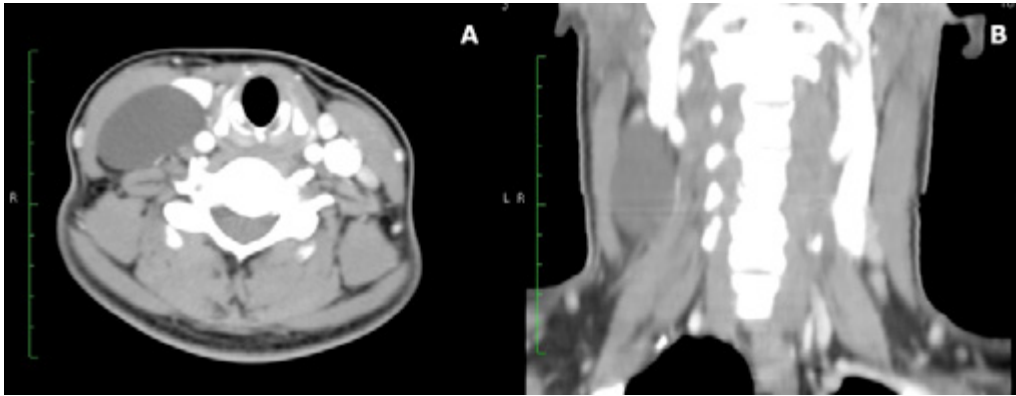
Contrast computed tomography of the neck. A) Thin-walled cyst medial to the sternocleidomastoid muscle; B) Cystic lesion occupying the right III and IV levels.
